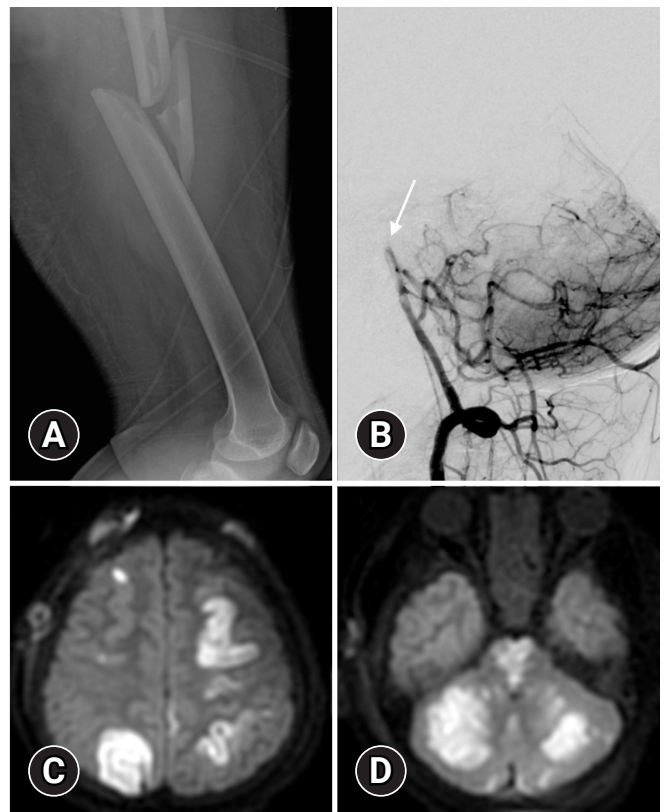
Multimodal imaging findings. (A) Acute comminuted left femoral shaft fracture. (B) Large vessel occlusion (arrow) in the mid basilar artery on digital subtraction angiography. (C) Multiple areas of diffusion restriction in the supratentorial brain on magnetic resonance imaging, consistent with cytotoxic edema. (D) Diffusion-weighted imaging signal abnormalities in the paramedian pons and bilateral cerebellar hemispheres on magnetic resonance imaging.
